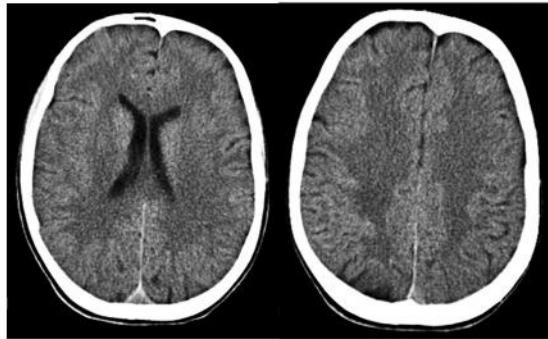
shows the normal Brain CT.
